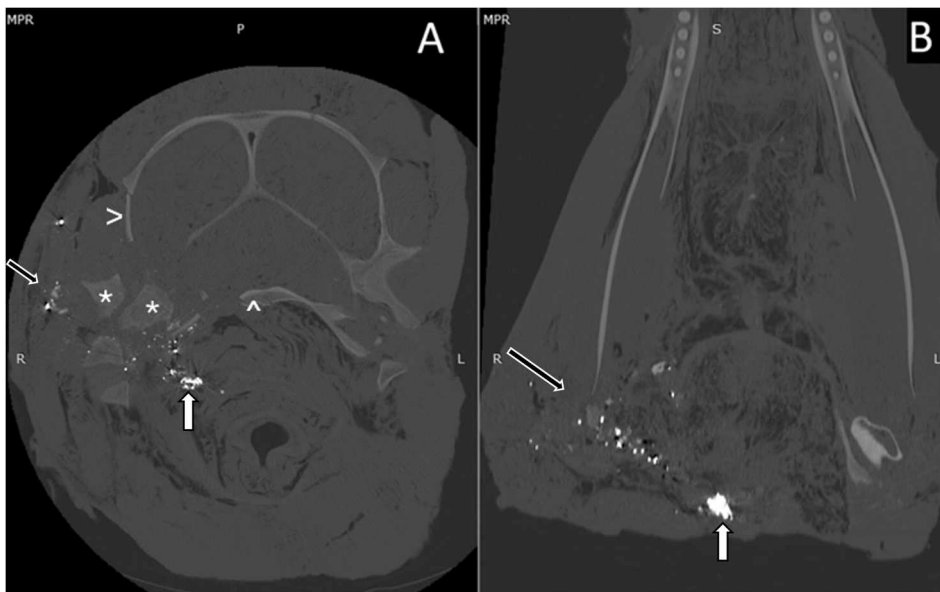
Multiplanar (A) transverse (at the level of tentorium cerebelli) and (B) dorsal reconstruction CT of bottlenose dolphin (*Tursiops truncatus*) 2 in a high-frequency algorithm with an extended CT scale (window width: 9,000 HU; window level: 2,000 HU) showing the initial caudo-ventral entry trajectory at the right lateral aspect of the head (black arrows) and the terminal trajectory of the metal bullet (white arrows). The right parietal bone (>), fractured right occipital bone (*), and basioccipital bone (^) are indicated.
